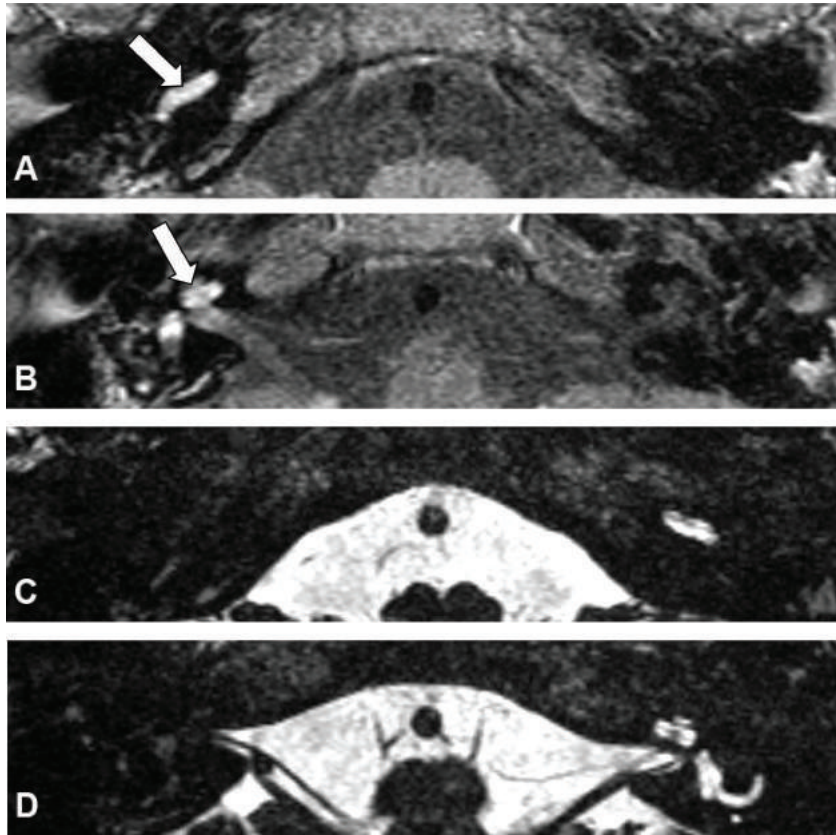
Unilateral cochlear inflammation and obliteration. Gadolinium enhanced T1-weighted MRI shows enhancement of the right-sided cochlea (A = basal turn, B = apical). 3D heavily T2-weighted MRI shows unilateral loss of fluid of the right-sided cochlea (C = basal turn, D = apical) (Patient 14). A non-enhancing cochlea on the contralateral side seems to predict the preservation of hearing in this ear. The patient was not implanted and good hearing remained.
